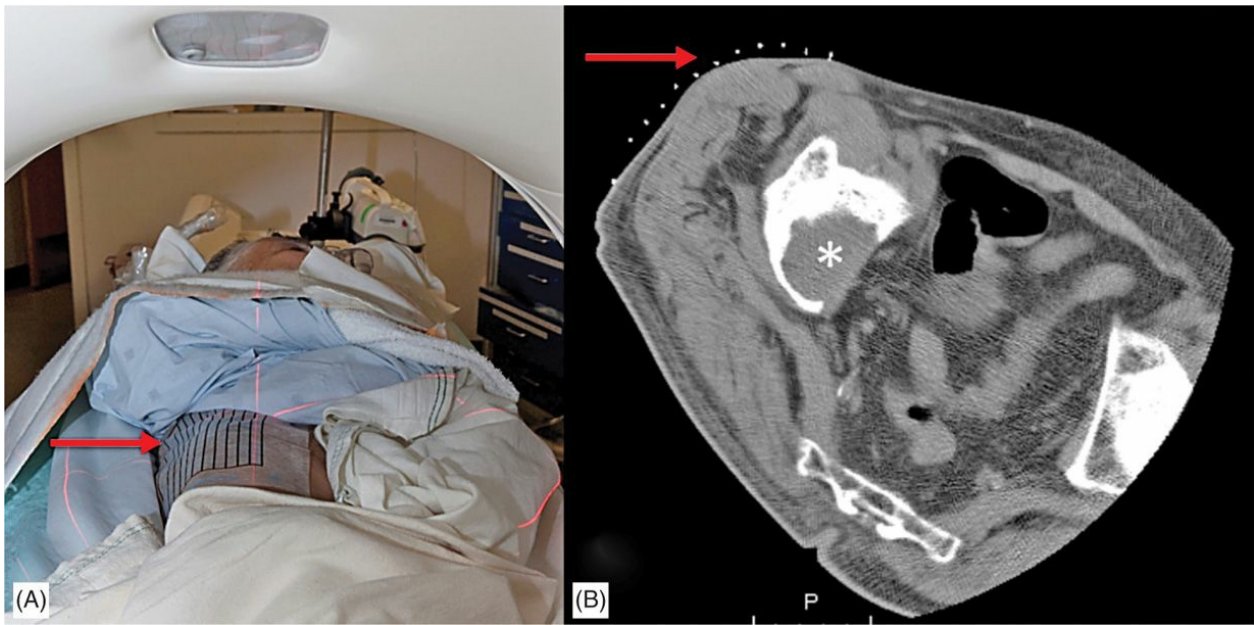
Use of skin grid to mark skin entry position. (A) Photograph of patient positioned prone oblique on CT table, with skin grid placed (arrow), and laser light used to mark entry position. (B) Corresponding CT image with skin grid markers (arrow) to guide needle trajectory into acetabular mass (star).
